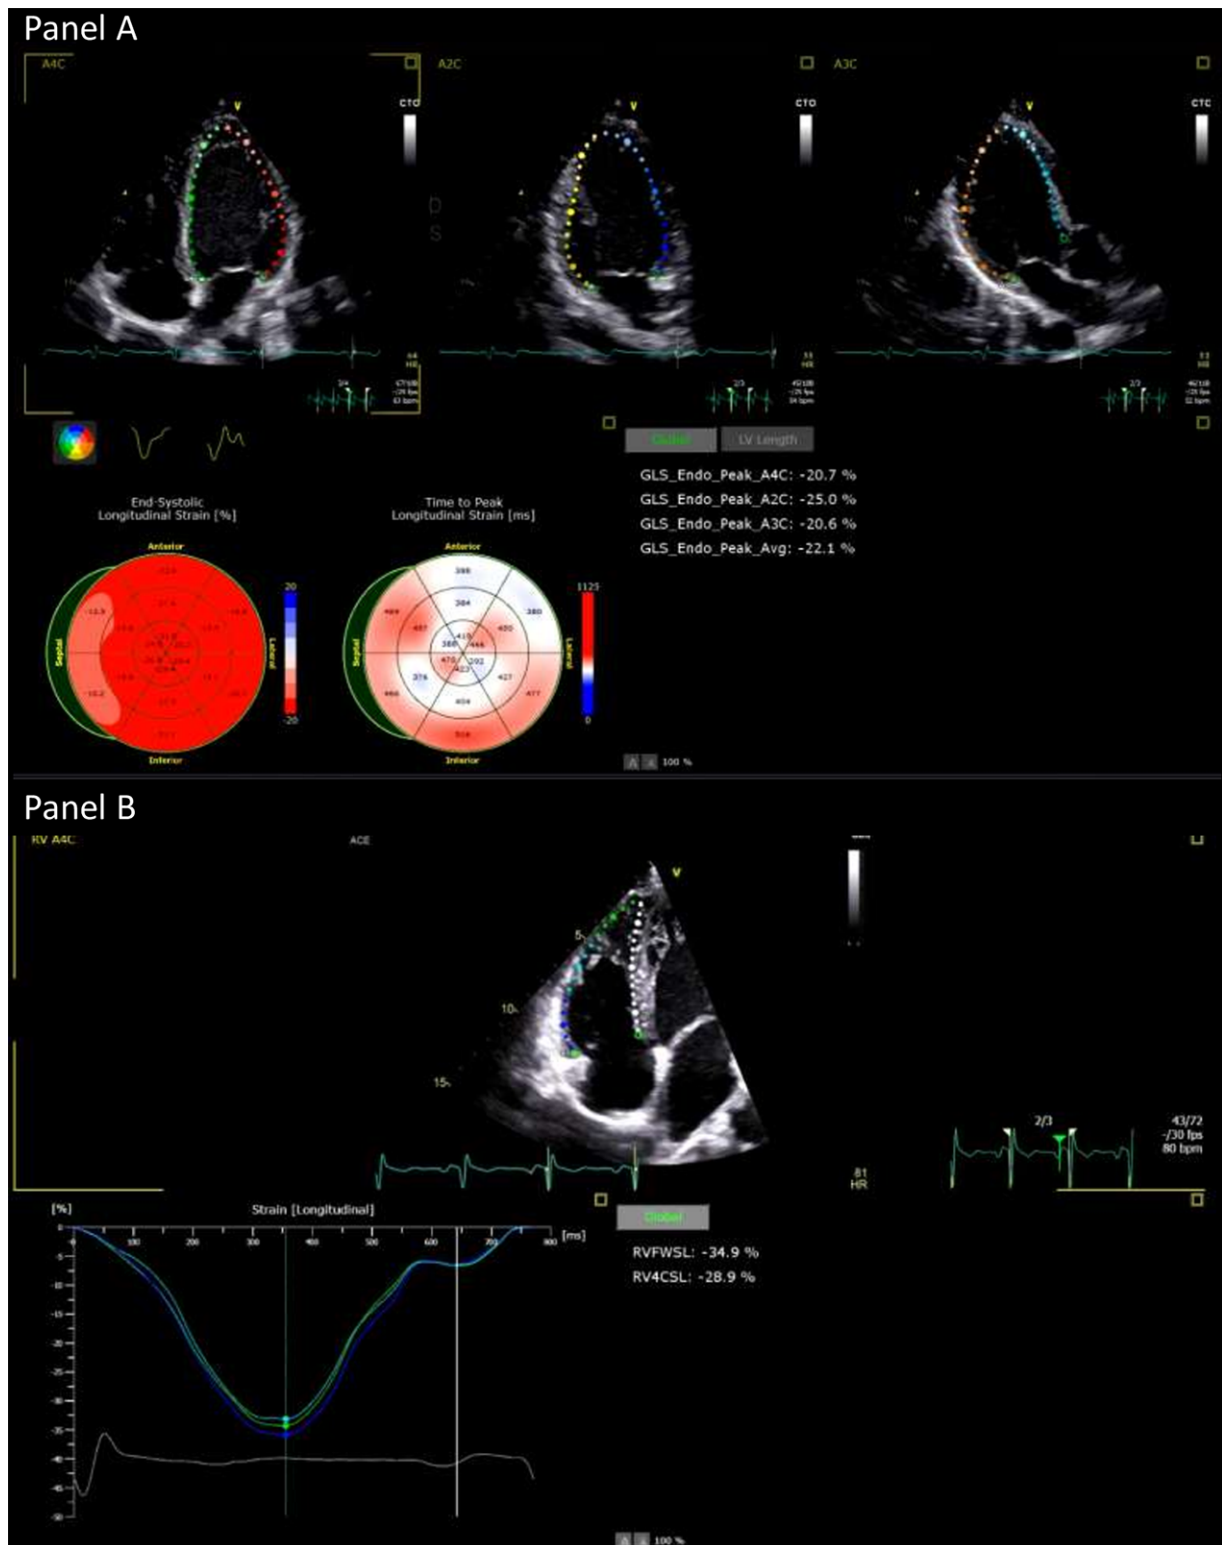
Speckle tracking echocardiography in a subject recently recovered from mild COVID-19 infection. (A) Strain echocardiographic evaluation of left ventricle showing normal absolute values of LV-GLS, but the basal segments presented significantly reduced values (light red in the GLS Bull's Eye plot on the left). (B) Speckle tracking echocardiographic evaluation of the right ventricle with absolute values of both RV-LS and RFW-LS in the normal range
